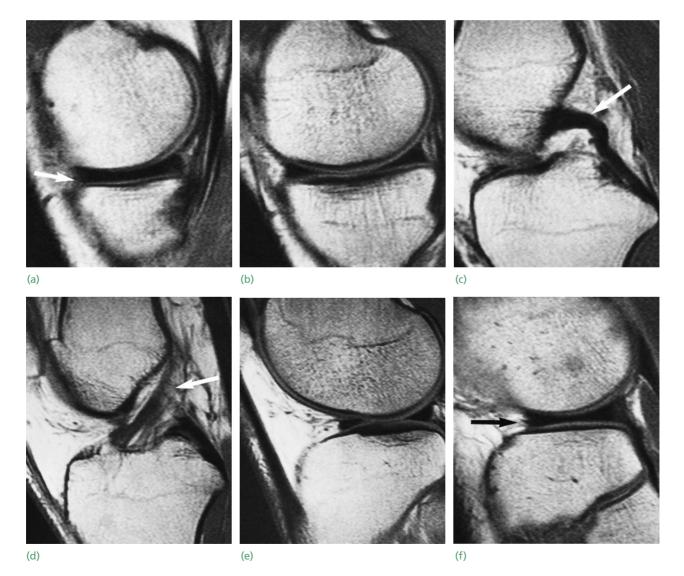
MRI A series of sagittal T1 weighted images proceeding from medial to lateral show the normal appearances of (a,b) the medial meniscus; (c) the posterior cruciate ligament; (d) the somewhat fan-shaped anterior cruciate ligament and (e,f) the lateral meniscus.
